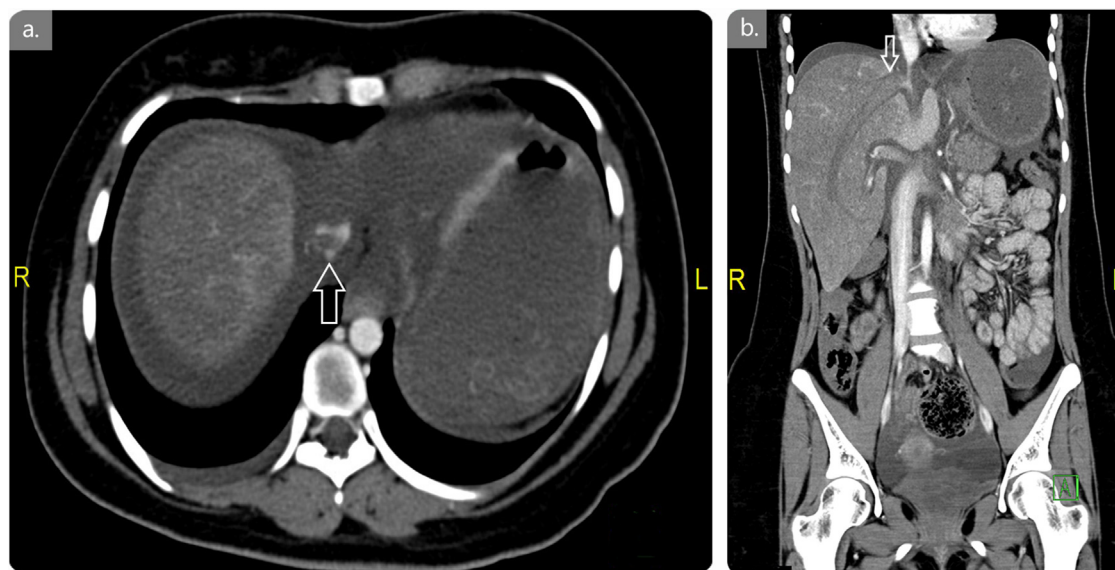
Enhanced CT scan of the abdomen.
